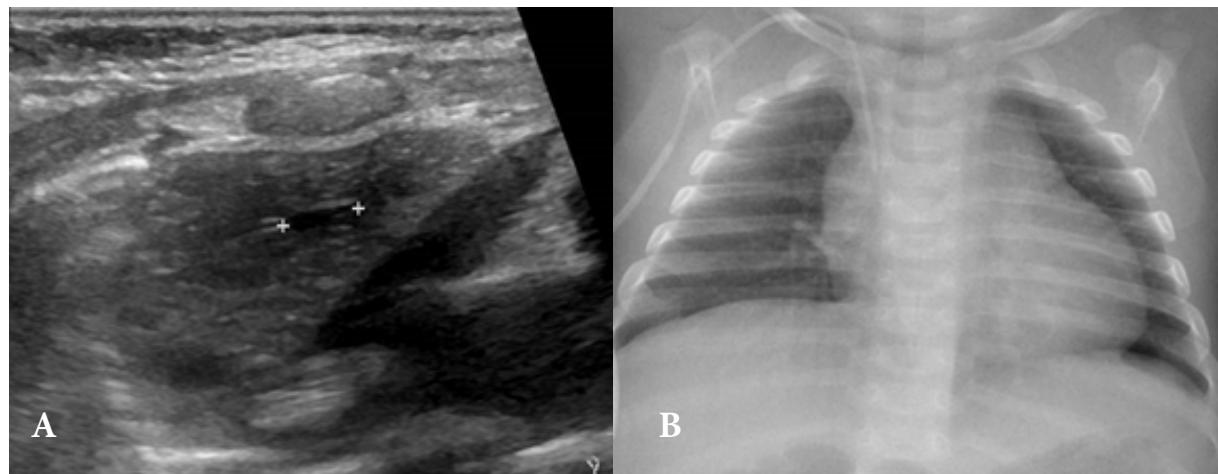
The subsequent 3-week follow-up chest ultrasound (A) showed thymic gland returning to a nearly normal size with residual tiny cystic areas. His chest radiograph on the same day (B) showed normal cardiothymic shadow, complete resolution of the left pleural effusion, and well-aerated lungs.
